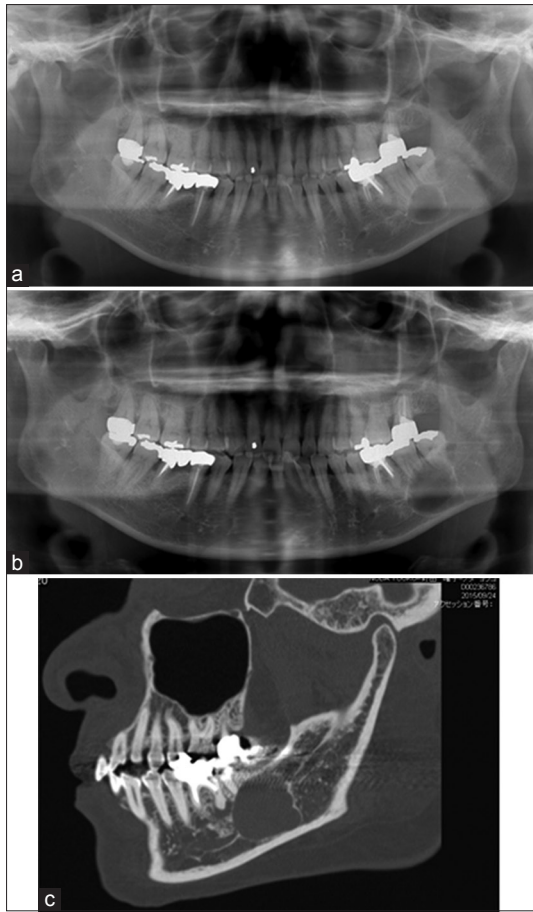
(a) Panoramic radiograph taken at the initial visit revealed the radiolucent lesion in the left body of the mandible. (b) Panoramic radiograph after 2-year follow-up. (c) Preoperative computed tomography scan. Sagittal section showed the lesion in the left body of the mandible
